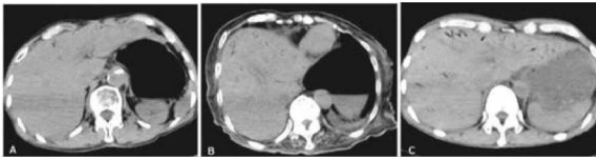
Multislice computed tomography of the abdomen, intrahepatic gas in the left lobe. (a) type 1, (b) type 2, (c) type 3. Source: Taken from Takahashi *et al.*^[56]
